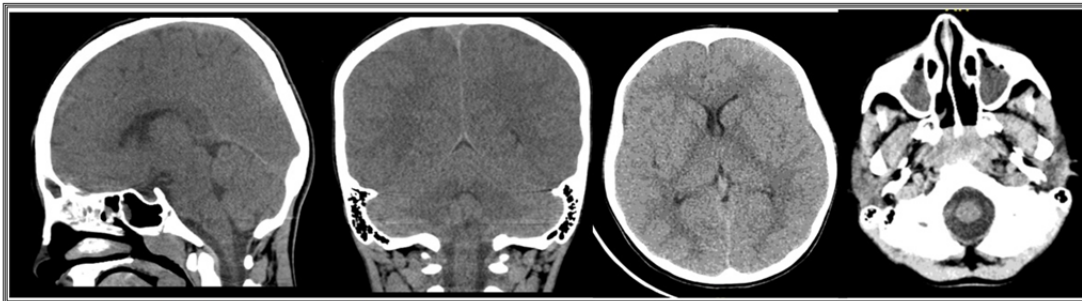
Normal brain CT before the LP
